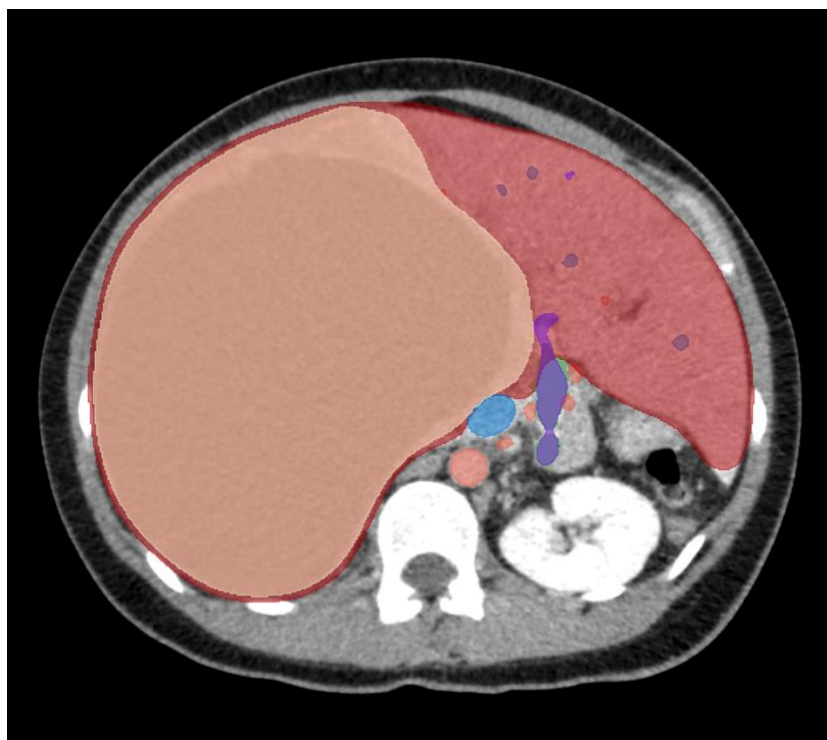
Same slice of a CT image segmented with Virtual Clone (above) and post-processed with 3D Slicer (below). Arteries are not represented because a CT in venous phase is shown.
